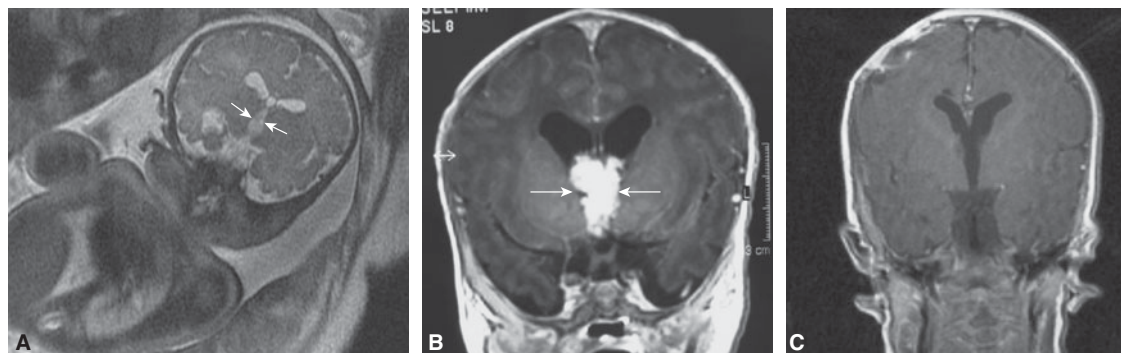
Prenatal and postnatal MRI in a patient with third ventricle CPP (same patient as in Figure 13-9). (A) Prenatal MRI at 40 weeks of gestation shows the CCP causing dilation of the third ventricle (arrows). (B) Postnatal MRI confirms the diagnosis (arrows). Note that the mass extends into the lateral ventricles. (C) Same plane at 10 months of age following surgical resection of the tumor. Normal neurologic and developmental follow-up was done at 4 years of age.
